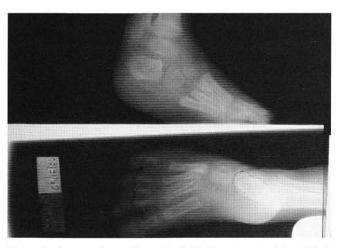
Preoperative radiographs indicating a non-existent Kite's angle on DP view, and a low calcaneal inclination angle with the inability of heel to purchase the floor.
